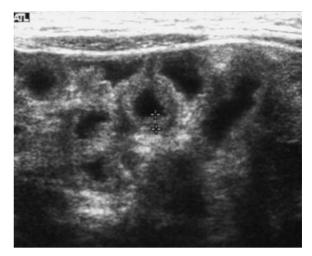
Ultrasound in a patient with celiac disease. Fluid filled, dilated small bowel with a thickened wall is demonstrated
